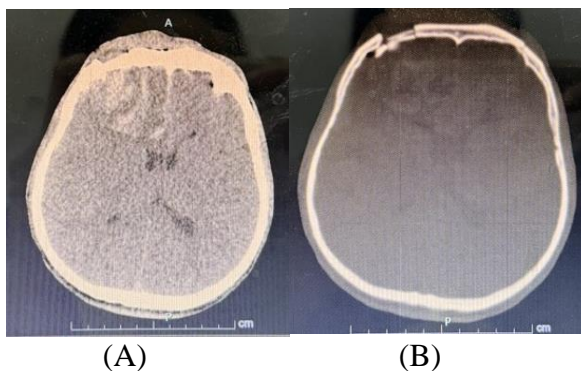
CT-scan shows intraparenchymal hemorrhage with perifocal edema and pneumocephalus in right frontal lobe and subarachnoid hemorrhage (A); CT-scan shows fracture of the frontal bone (B).
